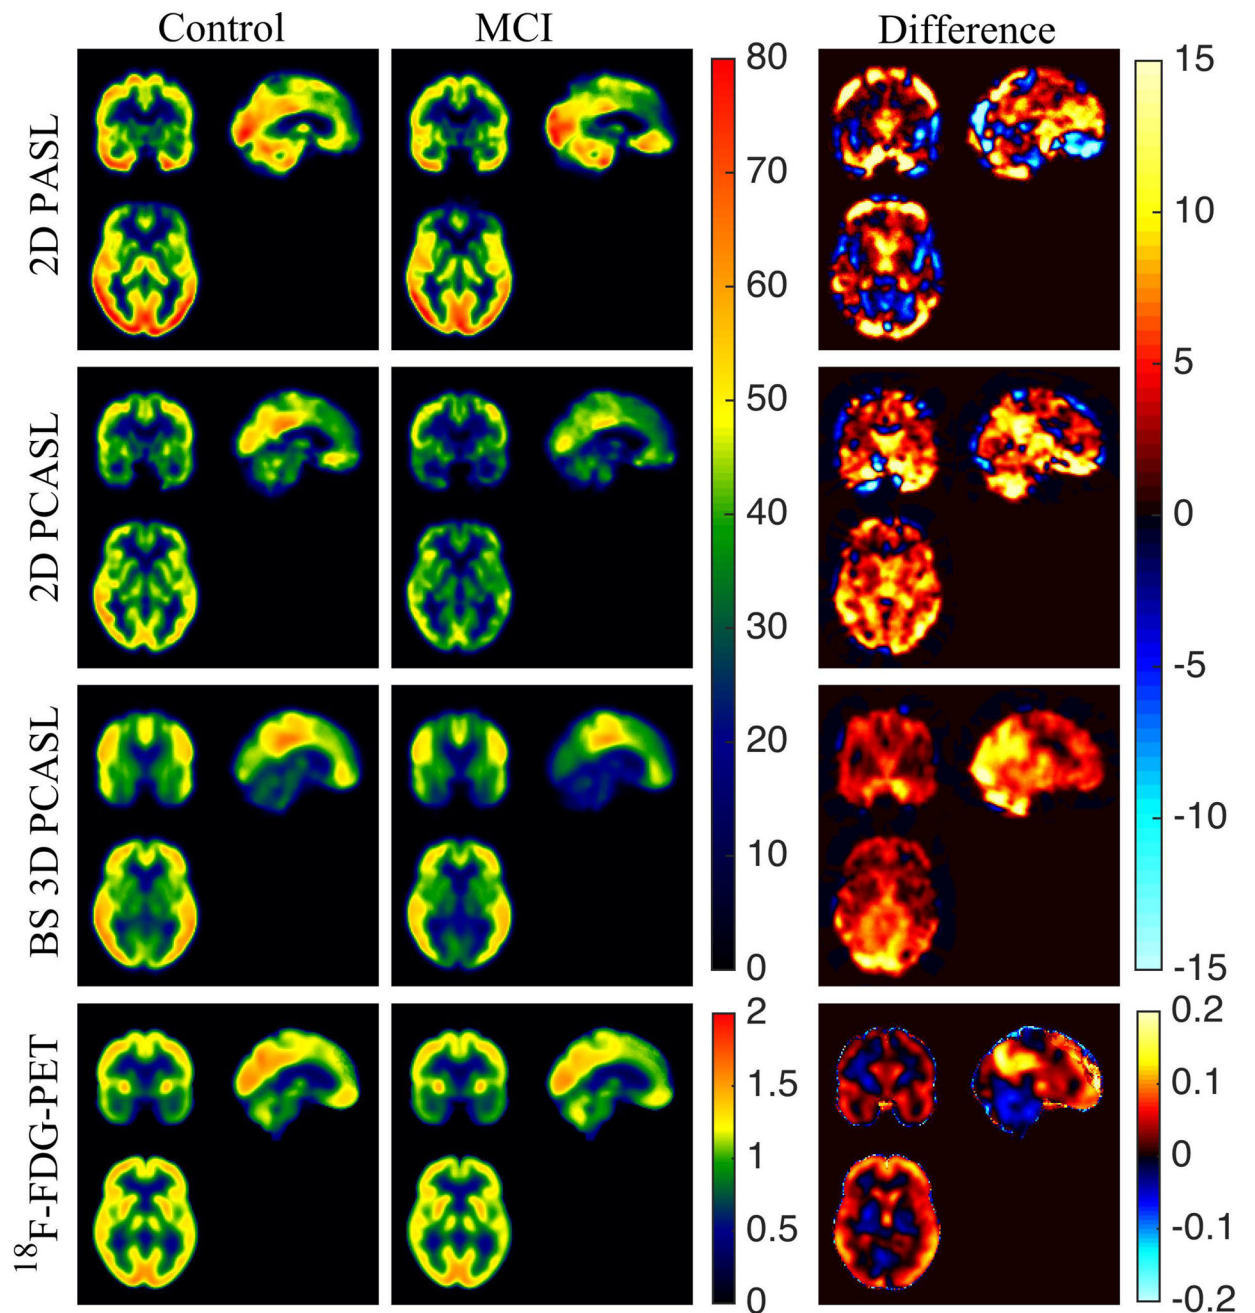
Triaxial view of mean CBF maps using 2D PASL (Row 1), 2D PCASL (Row 2) and BS 3D PCASL (Row 3) of a representative control subject on the left and MCI patient on the right. The bottom row shows the SUVR maps of the same subjects.
